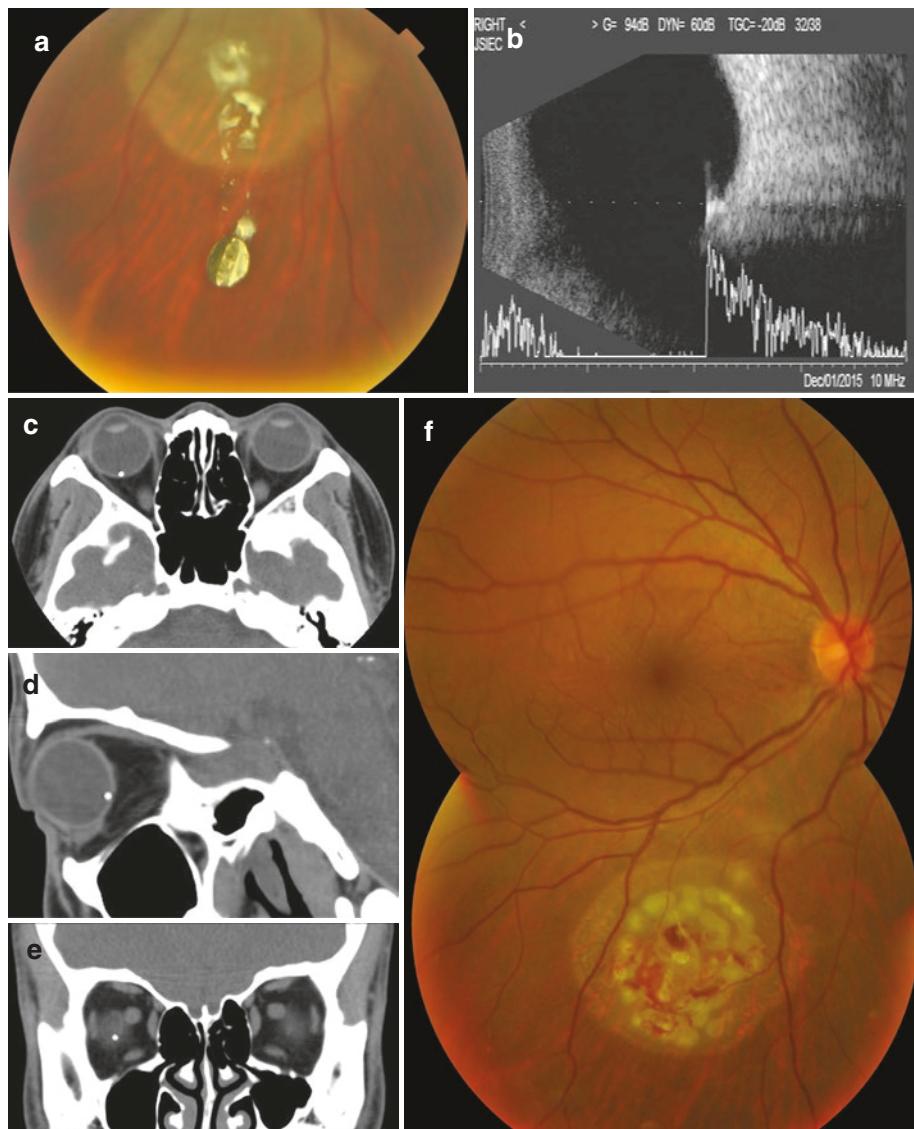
(a) Color fundus photograph, (b) ultrasound B scan, (c) horizontal, (d) sagittal, and (e) coronal planes. Computed tomographic scan of a patient with epiretinal
